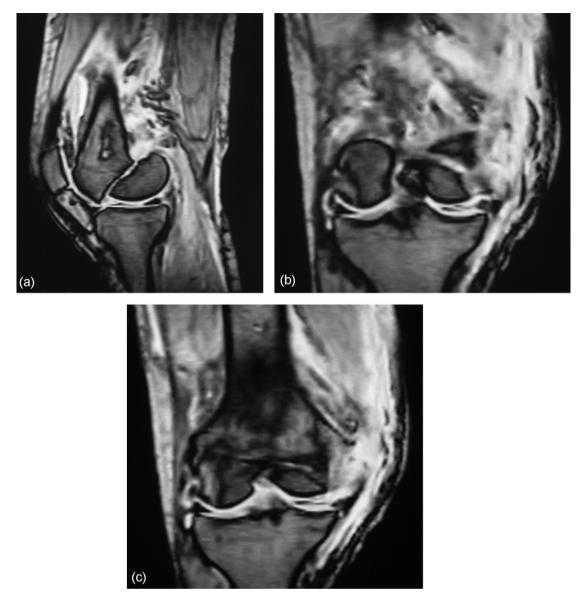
(a-c) Magnetic resonance images show Hoffa and eminentia fractures on coronal and sagittal planes.
